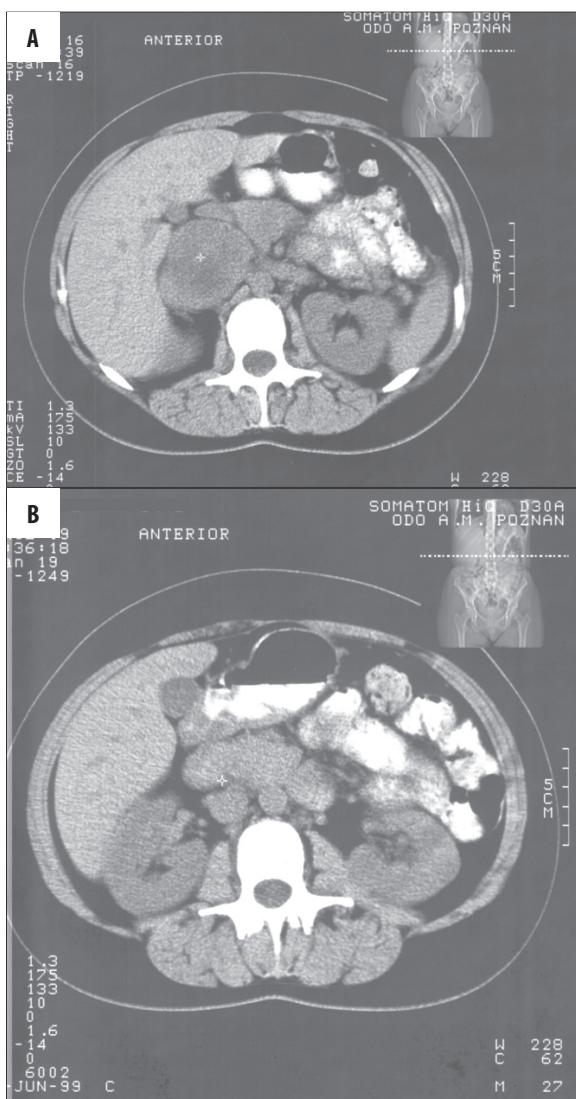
CT before intravenous contrast agent administration. (A) Heterogenic mass of tumor visible in the area of vena cava inferior. (B) No visible pathology within both kidneys.
